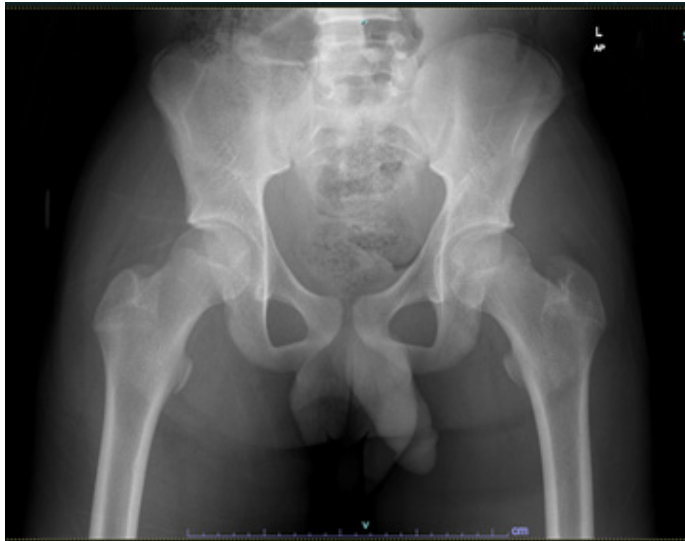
Pelvis X-ray of the patient.
